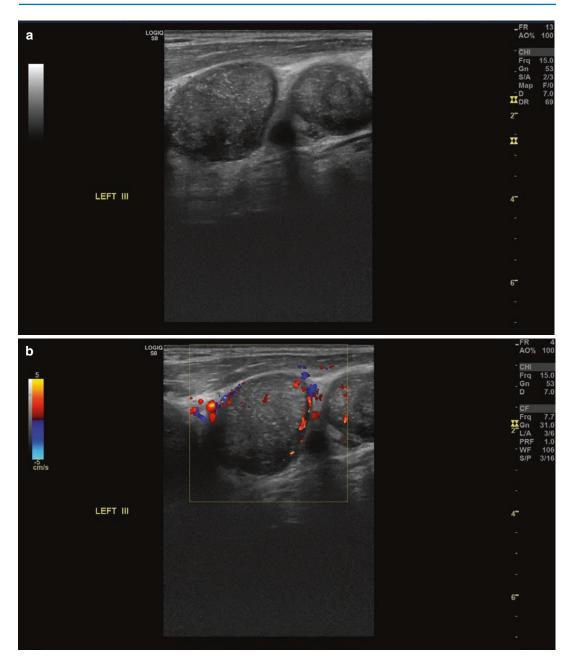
(a) Case of a Hodgkin lymphoma with multiple hypoechoic and round shaped nodes. Infiltration of the adjacent fatty tissue is present. (b) Same case with peripheral vascularity with the use of color Doppler
